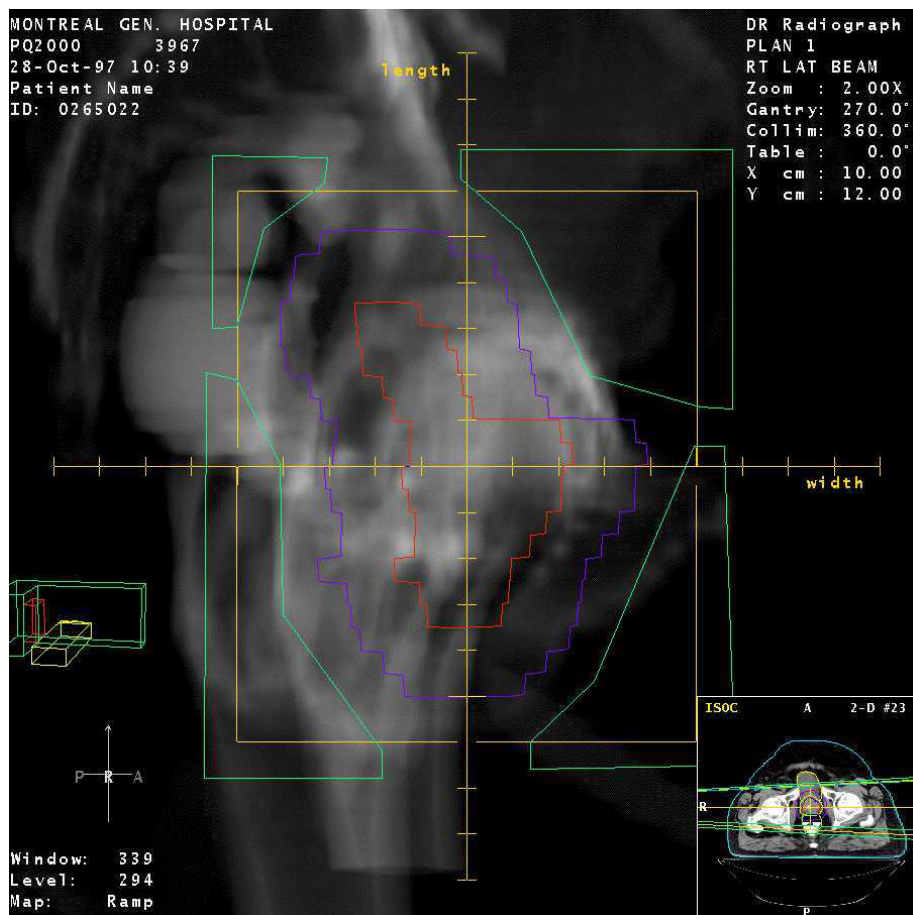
A digitally reconstructed radiograph (DRR) with superimposed beam's eye view for a lateral field of a prostate patient.
